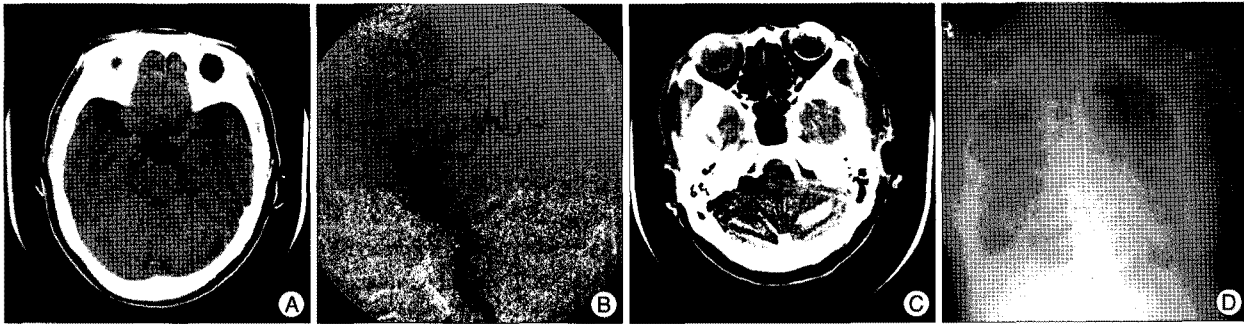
A 72-year-old woman admitted to our institution due to headache and left eye ptosis. A : Preoperative computed tomography (CT) showing calcification in both basal ganglia but no definite high-density area in the basal or sylvian cistern. B : Transfemoral cerebral angiography showing a wide-necked large aneurysm on the left posterior communicating artery. C : Postoperative CT scan showing a high-density area in the left cerebellum. D : The patient died due to aggravated pneumonia and sepsis.
